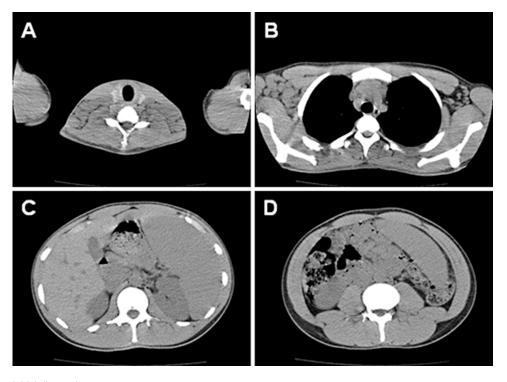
CT at initial diagnosis.
